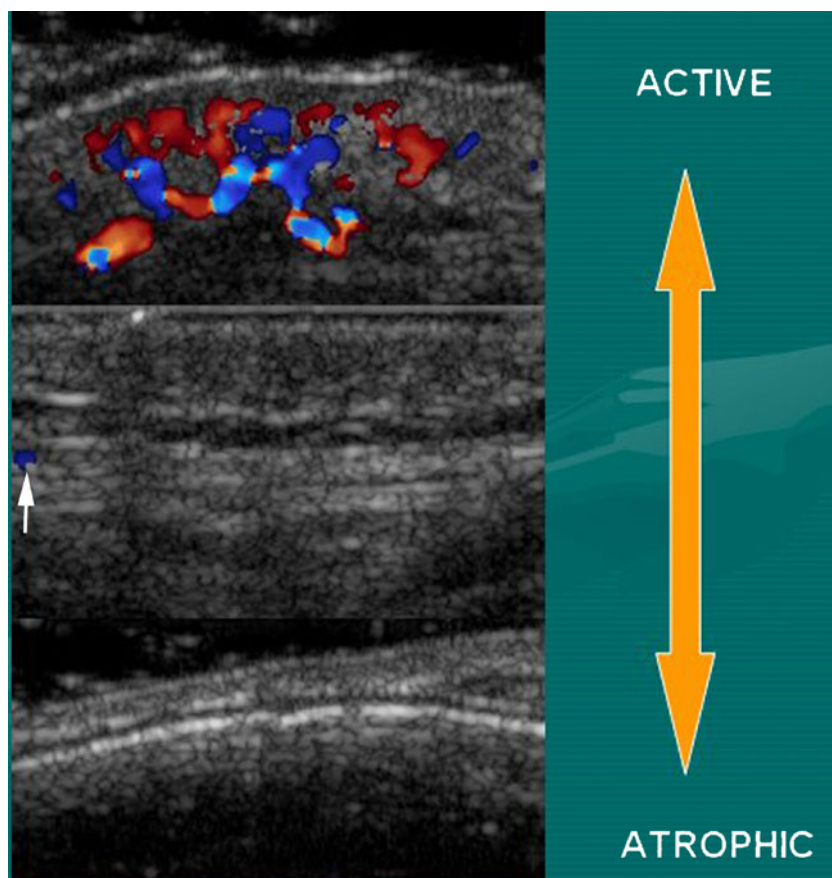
Activity phases of morphea on color Doppler ultrasound going from active/inflammatory (increased blood flow on colors, *top*) to atrophic (absence of hypervascularity, *bottom*)
